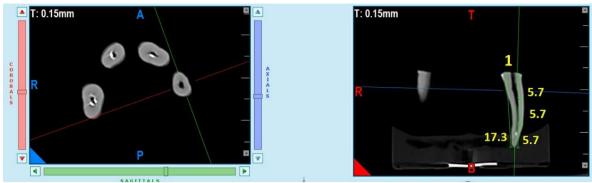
CBCT evaluation of teeth in which gutta percha has been removed using R-Endo file system
